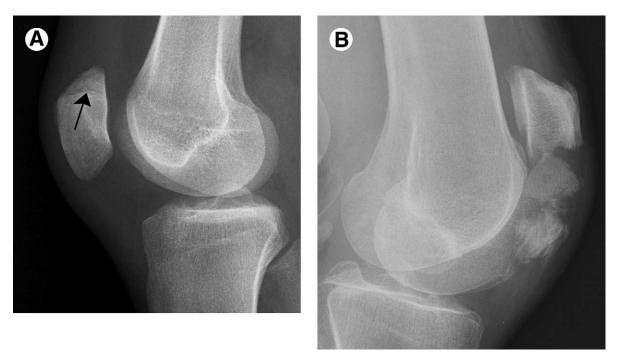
(A) Lateral knee radiograph demonstrates a non-displaced, transverse patellar fracture (arrow). (B) Radiograph of a comminuted patella fracture sustained during an automobile accident. Note the extensive articular disruption compared with (A).
